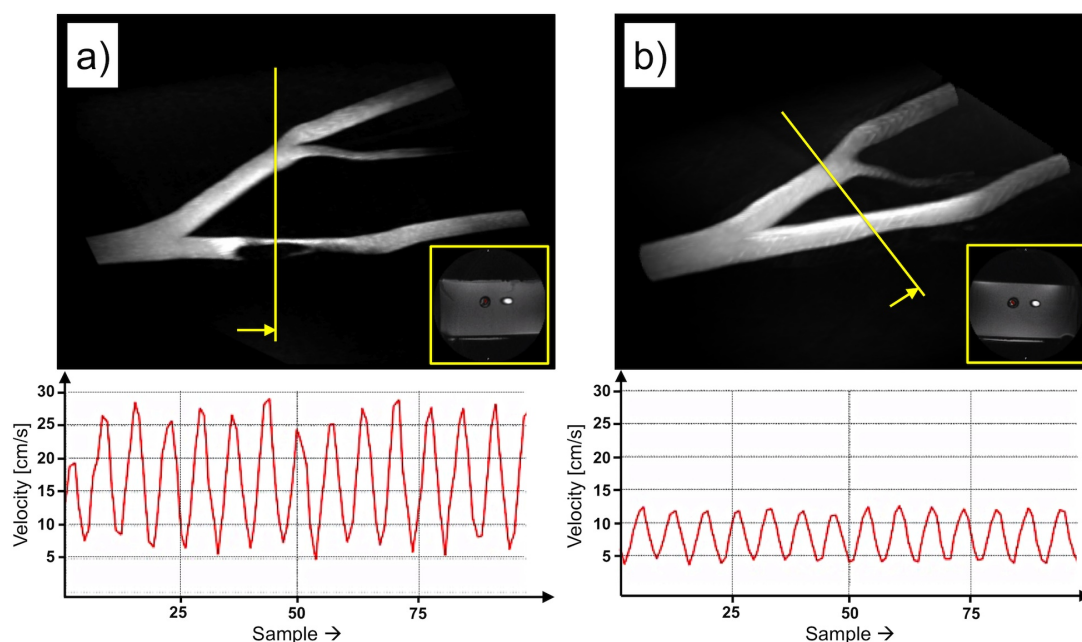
Flow/velocity examination performed in real-time and at various segments of the common iliac artery. The flow study at the level of the stenosis is shown exemplarily before (a) and after the stenosis treatment (b). The arrows in the MIP dataset (2D ToF) indicate the orientation of the flow-encoded axial images that are shown in the frame in the lower right corner of both MIP datasets. The flow patterns below the two MIP datasets are also obtained with real-time phase contrast (rtFLOW) MRI and demonstrate the velocity profile averaged over a ROI, which was positioned within the vessel segment of interest (ROI not shown for simplicity).
